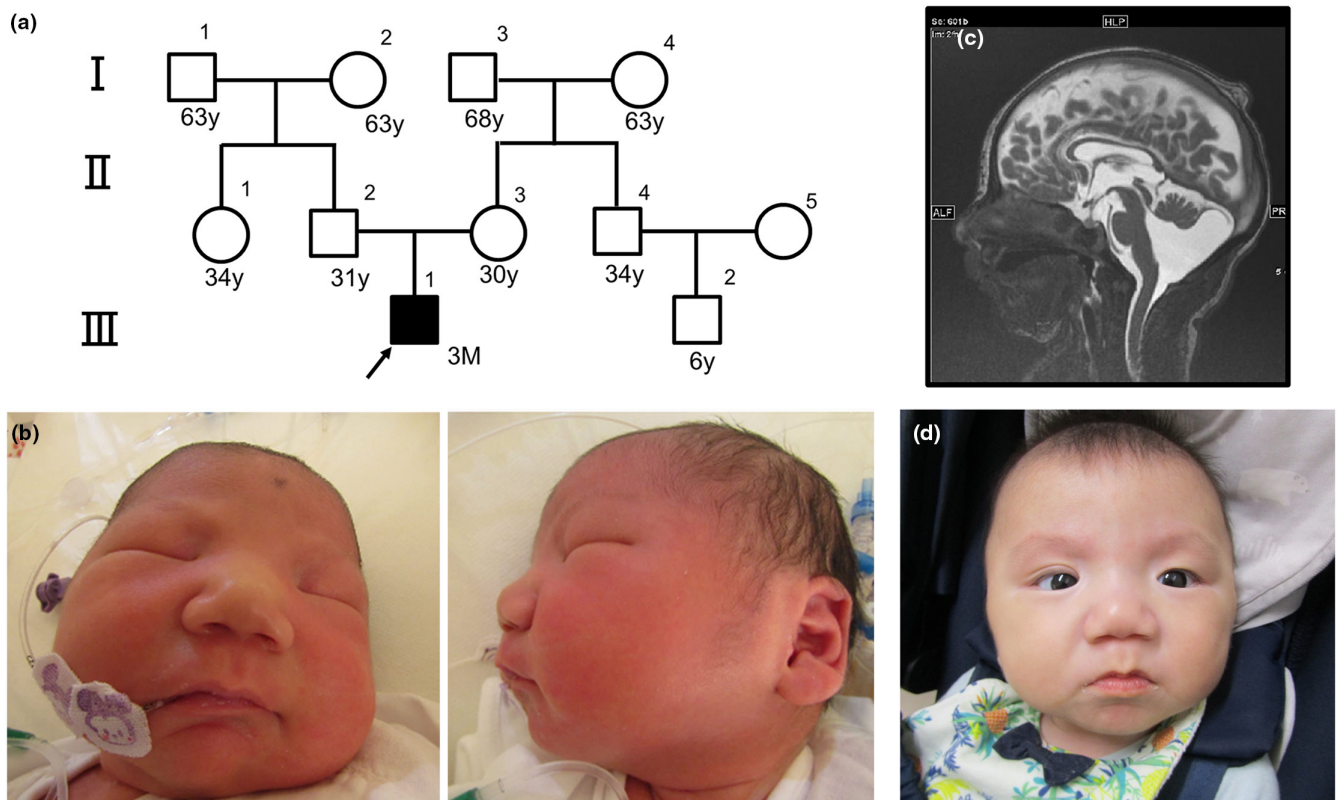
(a) Family tree of the patient. (b) Photograph of the patient at admission. (c) Postnatal head MRI showed Blake's pouch cyst. (d) Photograph of the patient at 7 months old.
